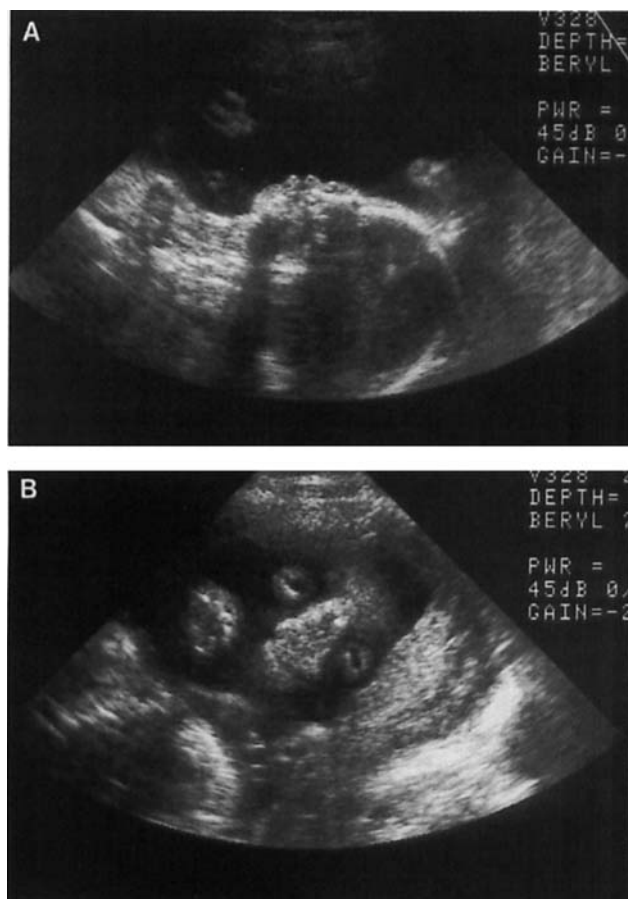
Ultrasonography of the severely affected fetus in the second trimester. A: Sagittal (profile) view of fetus shows virtually complete absence of nose and micrognathia. B: Note typical slanted eyelids on coronal view of fetus.
